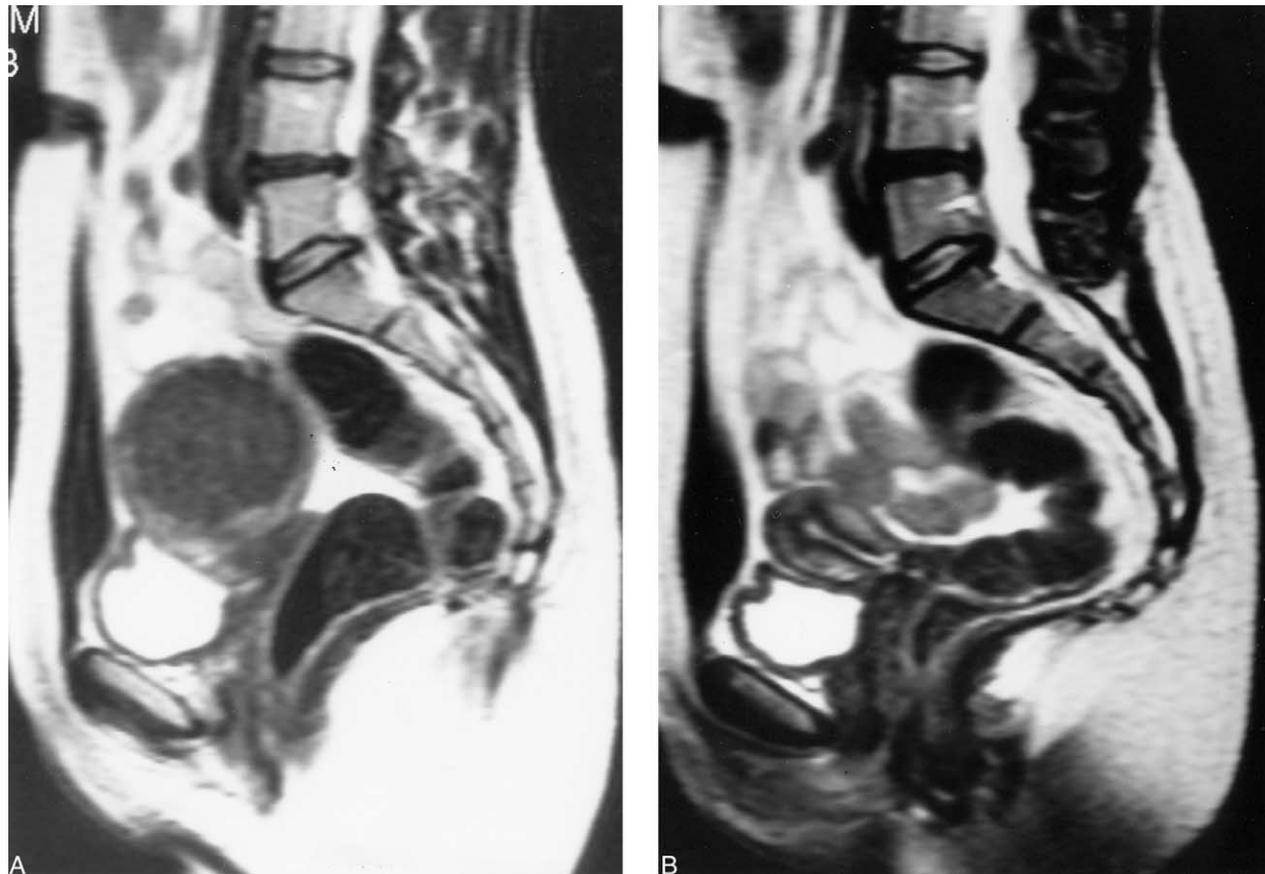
T2-weighted sagittal magnetic resonance imaging performed two months after embolisation demonstrates a large submucous fibroid about to be expelled through the cervix.
